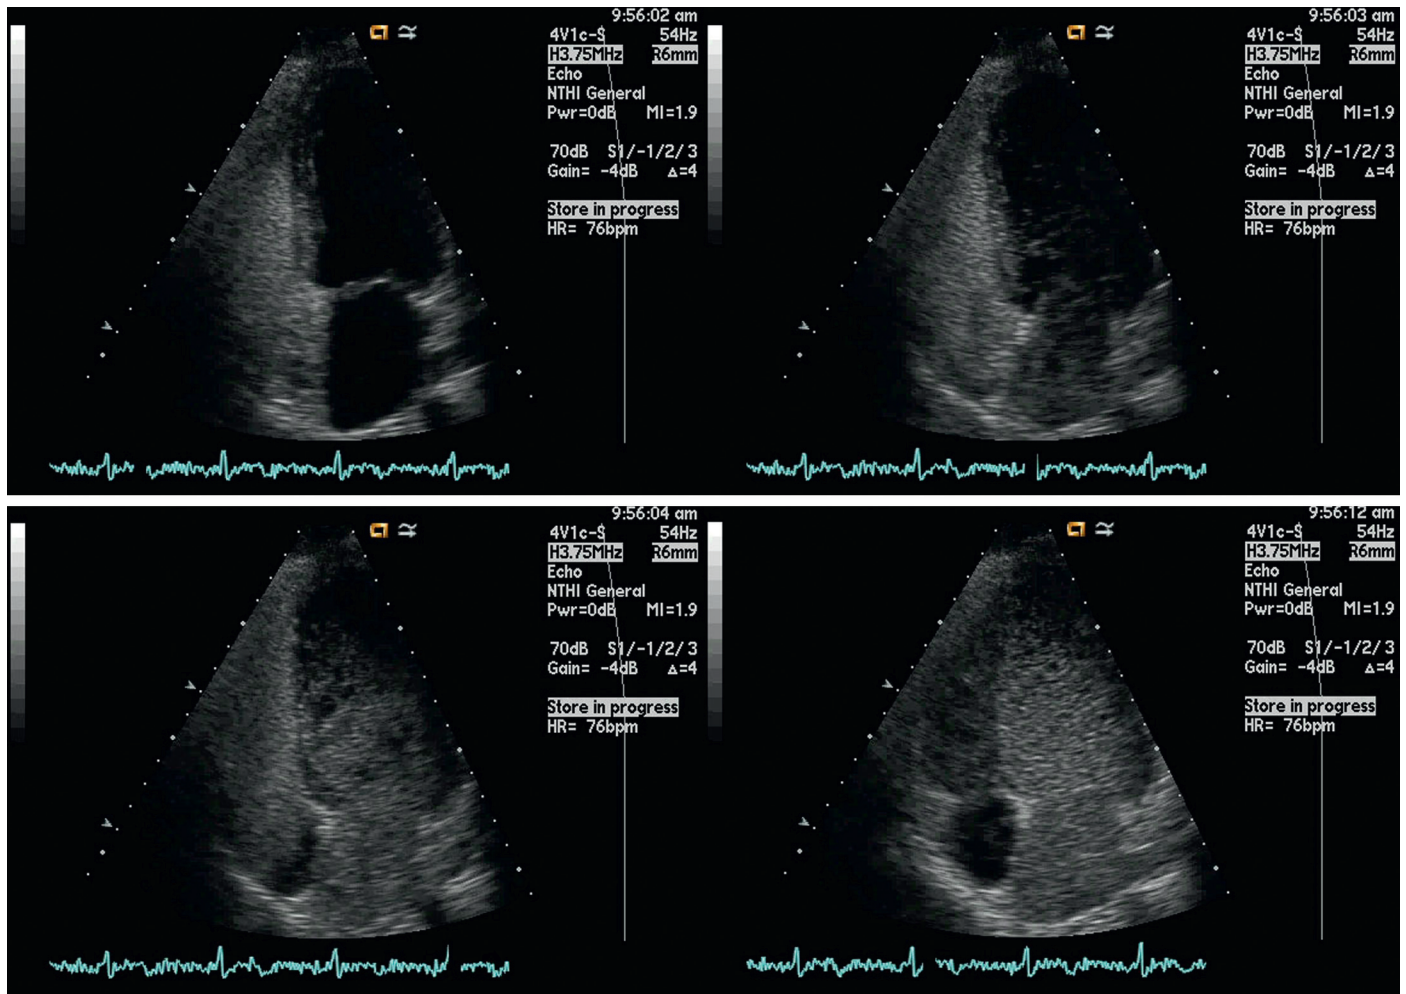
■ Photos of contrast-enhanced echocardiography. Top left: Agitated saline enters the right ventricle. Top right: Saline enters the left atrium posteriorly. Bottom left: Saline density is equal in the right and left ventricles. Bottom right: Saline density in the left ventricle exceeds the right ventricle after multiple cardiac cycles. (Photos courtesy of Karl Q. Schwarz, MD. University of Rochester Medical Center, Rochester, NY.)
